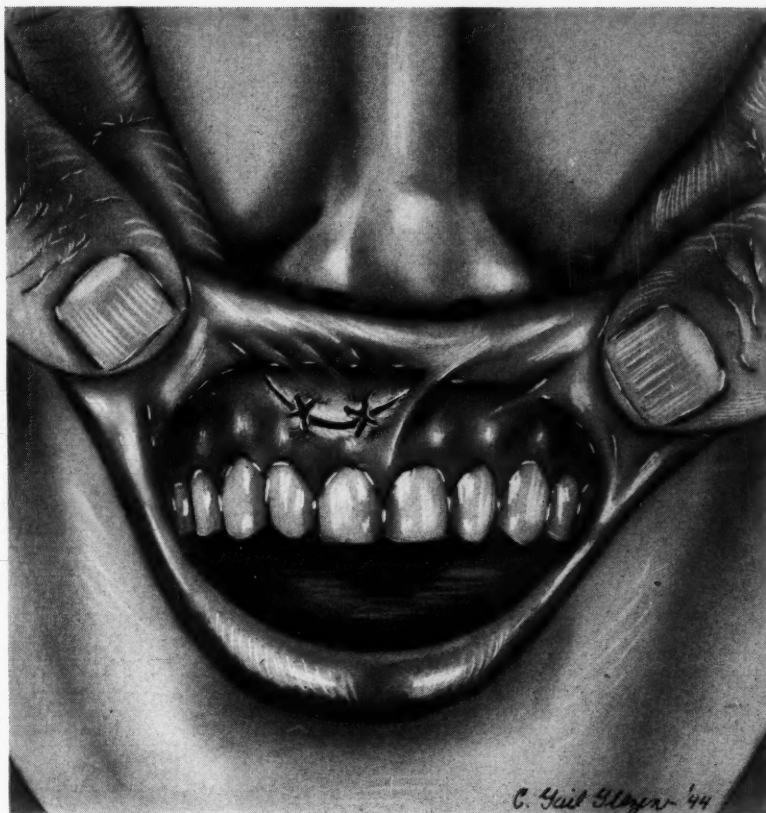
The incision made for the removal of the periapical cyst is closed with two sutures.
